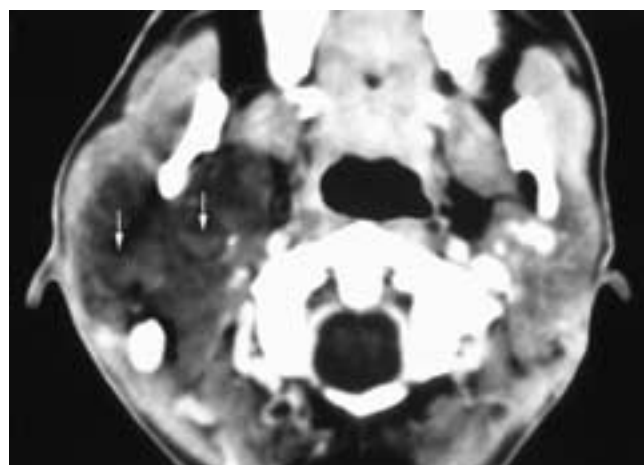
Axial contrast-enhanced CT scan through the parotid gland shows a low-attenuation, partially cystic mass in the right parotid gland. The lesion extends into the parapharyngeal space and caudally into the neck. Fluid-fluid levels are present within the mass (*arrows*). This child presented with a parotid mass and facial nerve paresis. The patient had a cystic lymphangioma of the parotid gland, with hemorrhage compressing the facial nerve.
